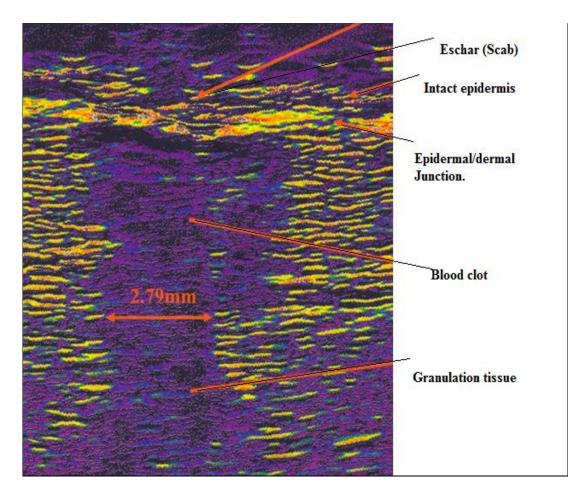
Shows high resolution ultrasounds scan of healing skin 7 days after a full thickness punch biopsy (Taken from Morison et al, 2004).
